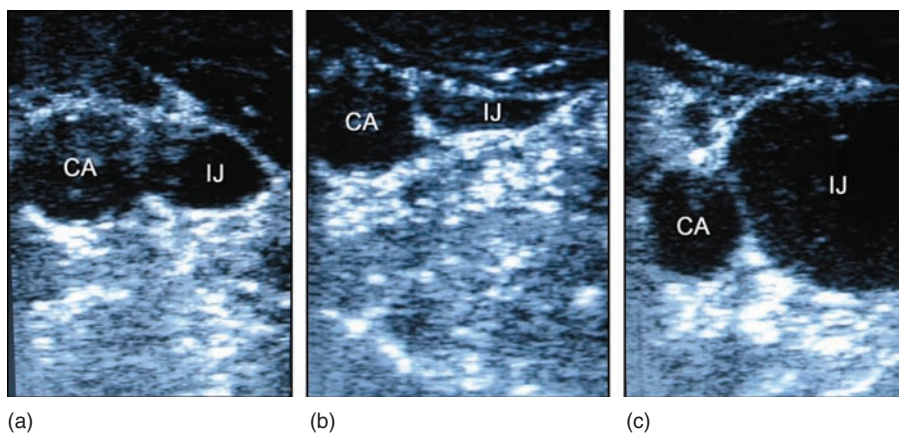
Ultrasound-guided internal jugular vein puncture. (a) The carotid artery is seen medial to the vein. (b) Gentle compression distinguishes the vein. (c) A Valsalva maneuver from the same patient distends the vein. IJ: internal jugular vein; CA: carotid artery.
